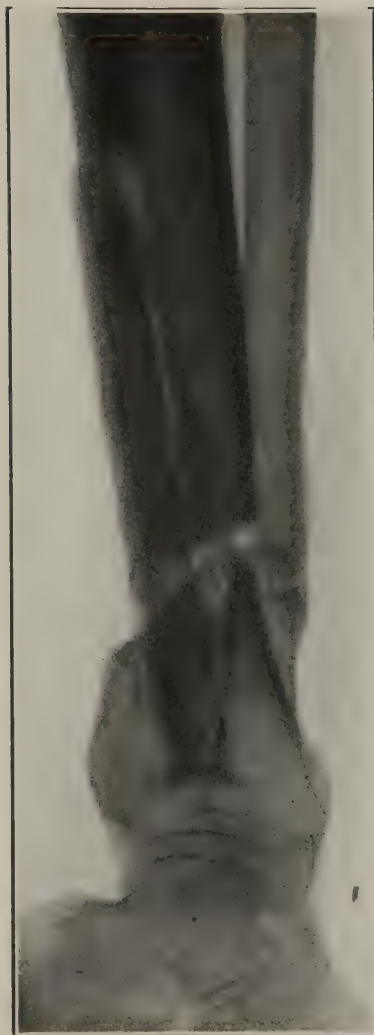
Case 15. Lateral roentgenogram
